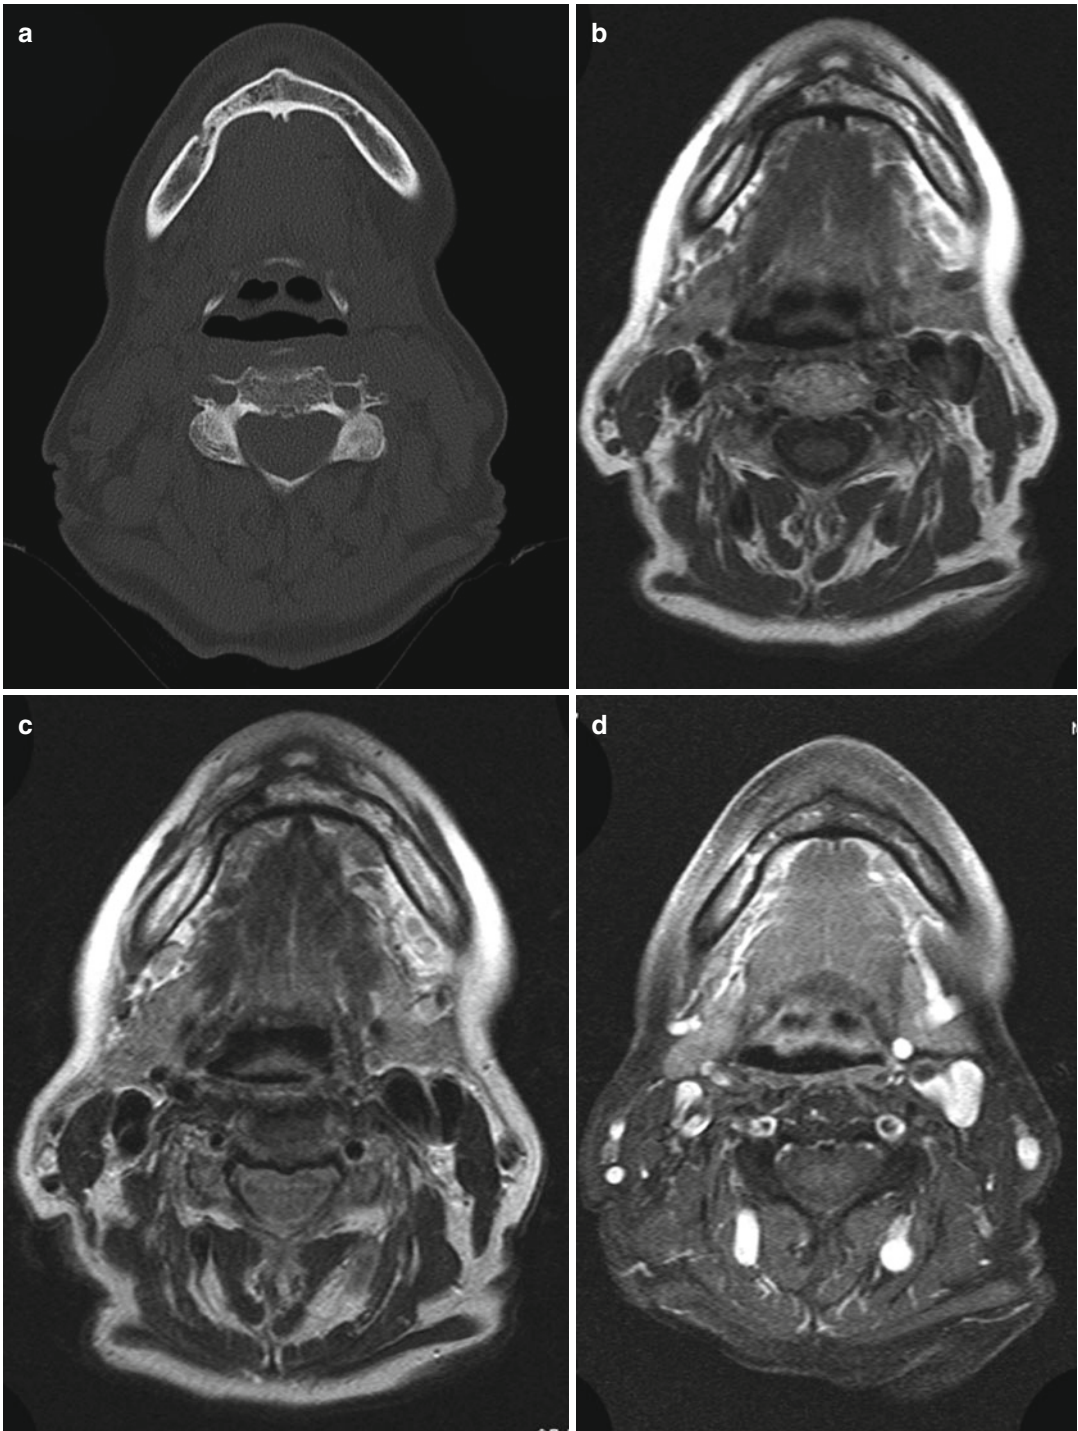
(a–d) A 54-year-old woman with breast cancer and intermittent pain on the right mandible. Axial CT image (a) shows subtle focal sclerosis on the right mandible next to the mental foramen. The suspected area appears with low signal intensity on unenhanced T1-weighted (b)
